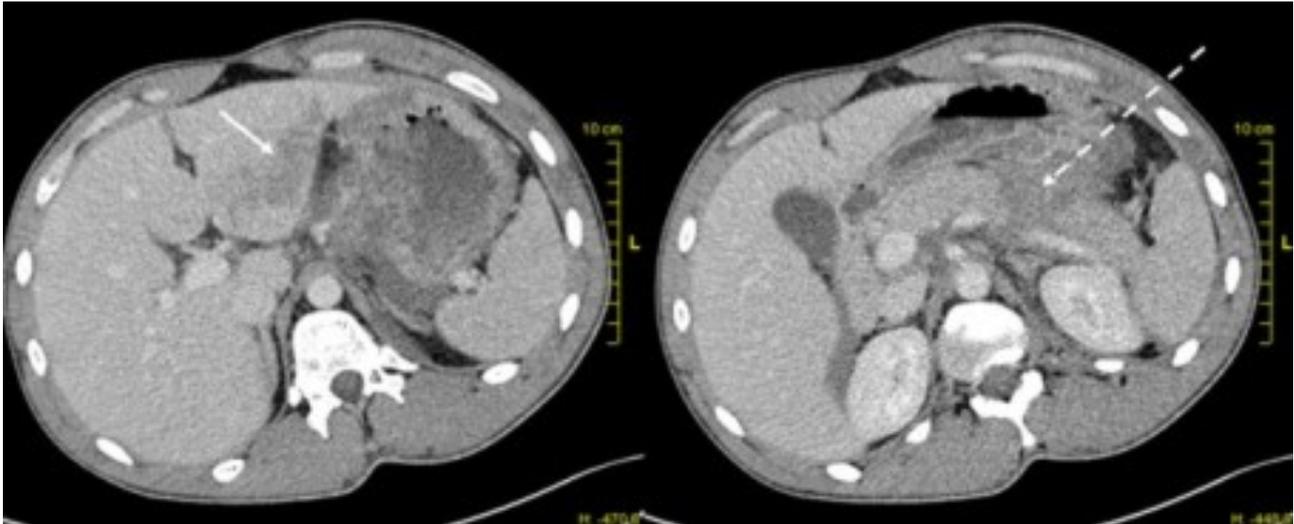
CT scan showing a moderate contusion of the left liver (arrow), and a complete fracture between the body and the tail of the pancreas with an hematoma in front of the splenic vein (dotted arrow).
